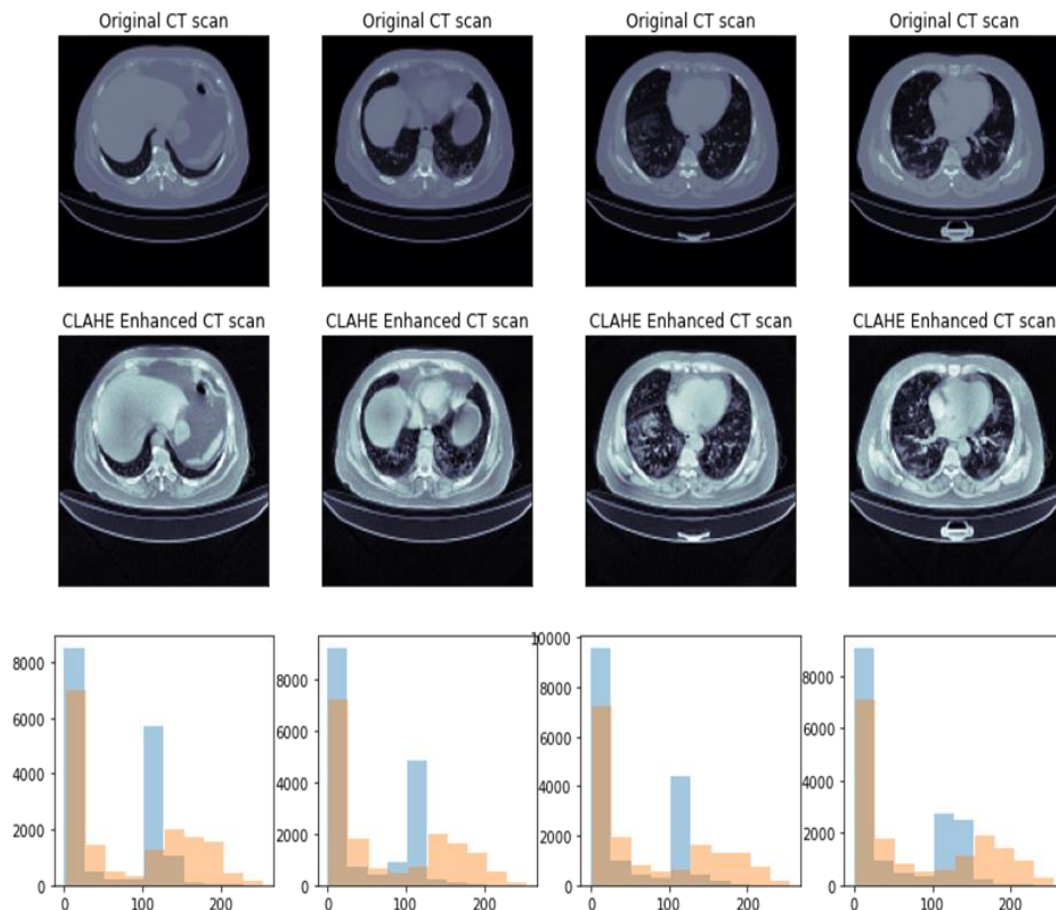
visualization of CLAHE enhancement on CT scans of COVID-19
